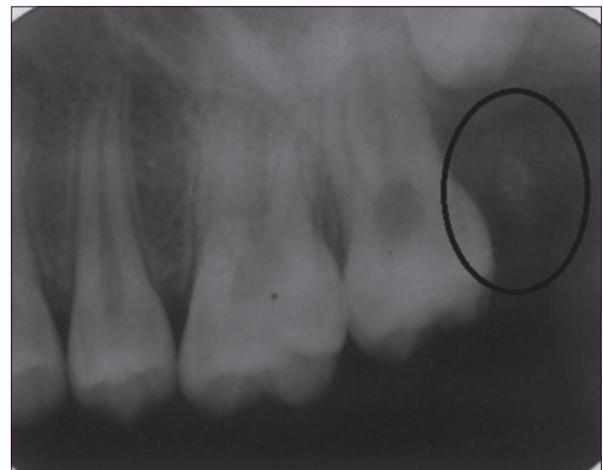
Intraoral periapical radiograph showing calcified flecks distal to 27
